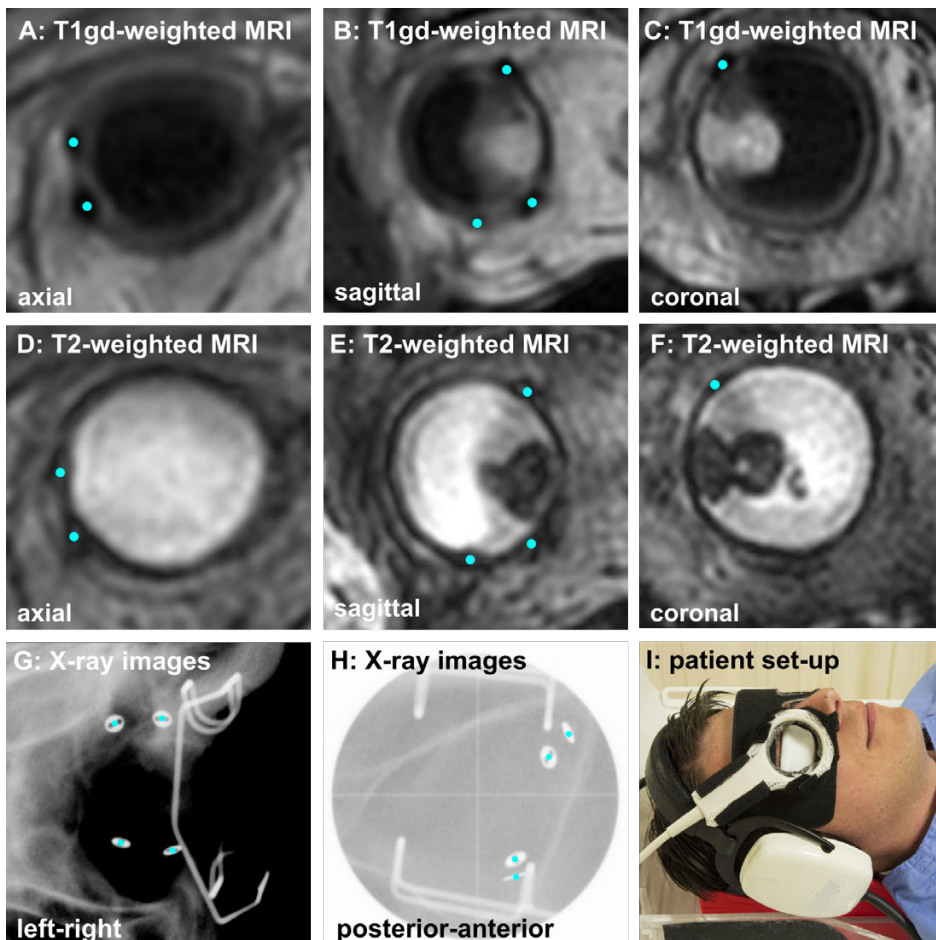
Images used in the patients: 3D contrast-enhanced T1-weighted (T1gd) MRI (A-C), 3D T2-weighted MRI (D-F), and X-ray images (G,H) and the patient set-up (I). Tantalum clips were identified on MRI and X-ray images by three observers.
